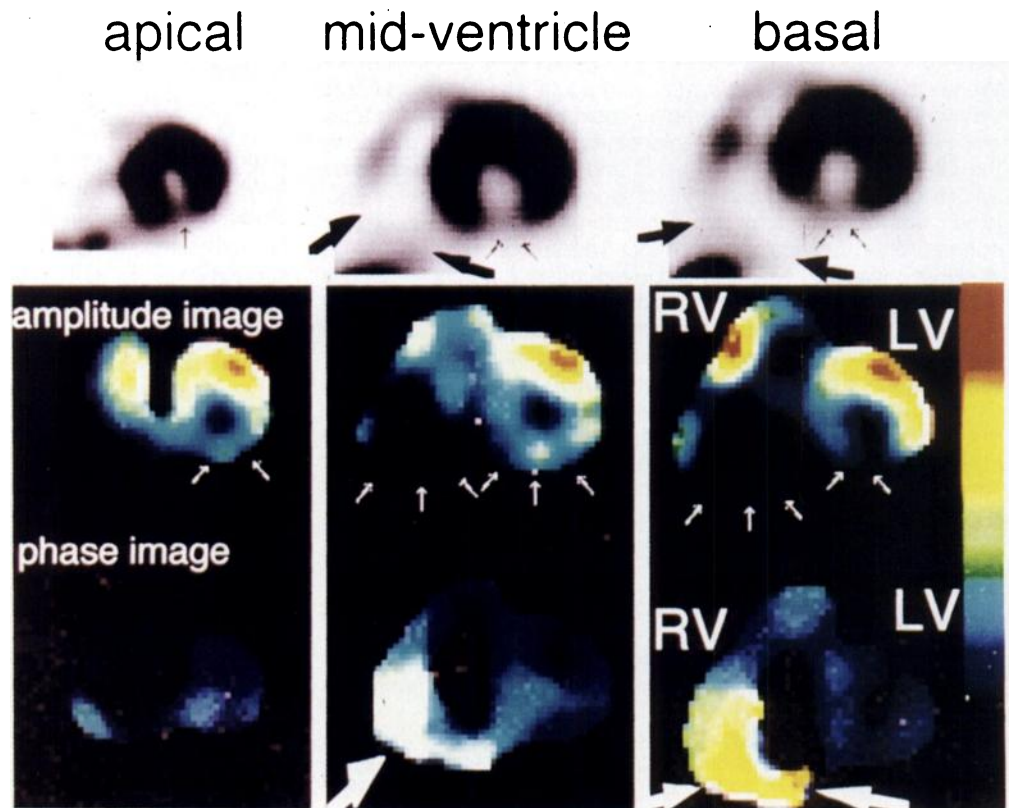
Apical, mid-ventricular and basal short-axis tomograms of ^{99m}Tc -tetrofosmin scintigraphy (upper panels) and radionuclide ventriculography (middle and lower panels) 4 yr after myocardial infarction. Amplitude images (middle panels) clearly demonstrate reduced wall motion in the inferior segments of both ventricles (small white arrows), which well correspond to perfusion defects of left (small black arrows), and right ventricles (large black arrows). Note that markedly delayed phase angles are observed in the RV inferior segments (white large arrows in lower panels) showing perfusion defects. Abbreviations are the same as in Figure 1.
